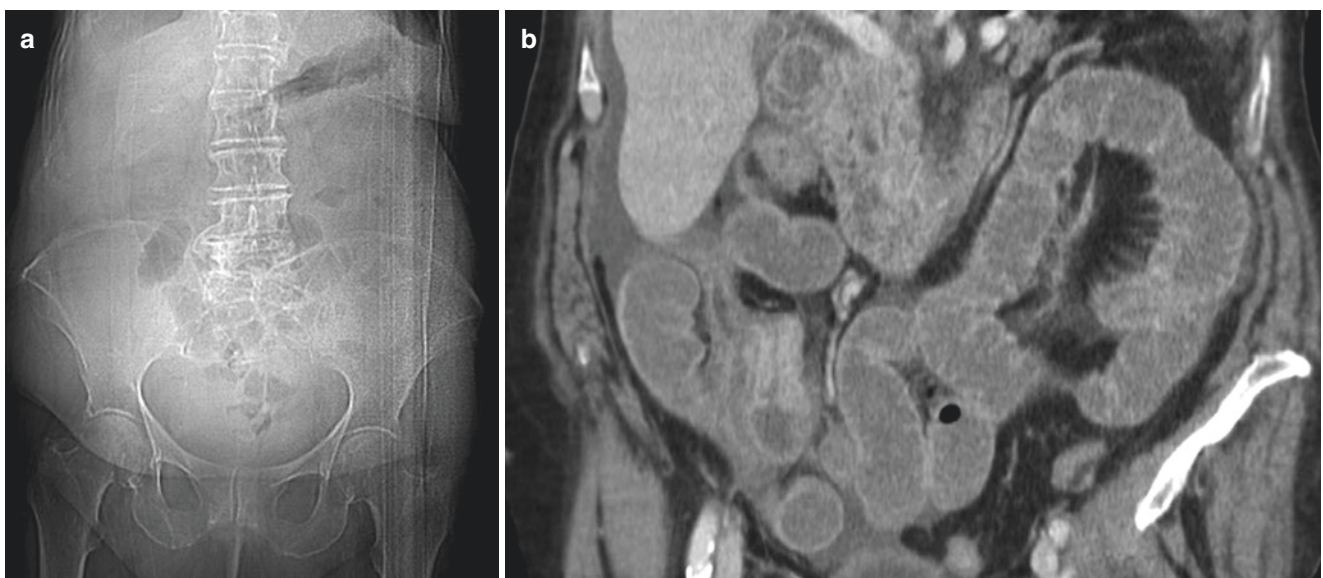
(a) Small bowel obstruction on a KUB x-ray due to metastatic lobular breast cancer. (b) Coronal CT image revealing a segmental stricture in the right lower quadrant with thickened enhancement of the small bowel wall
